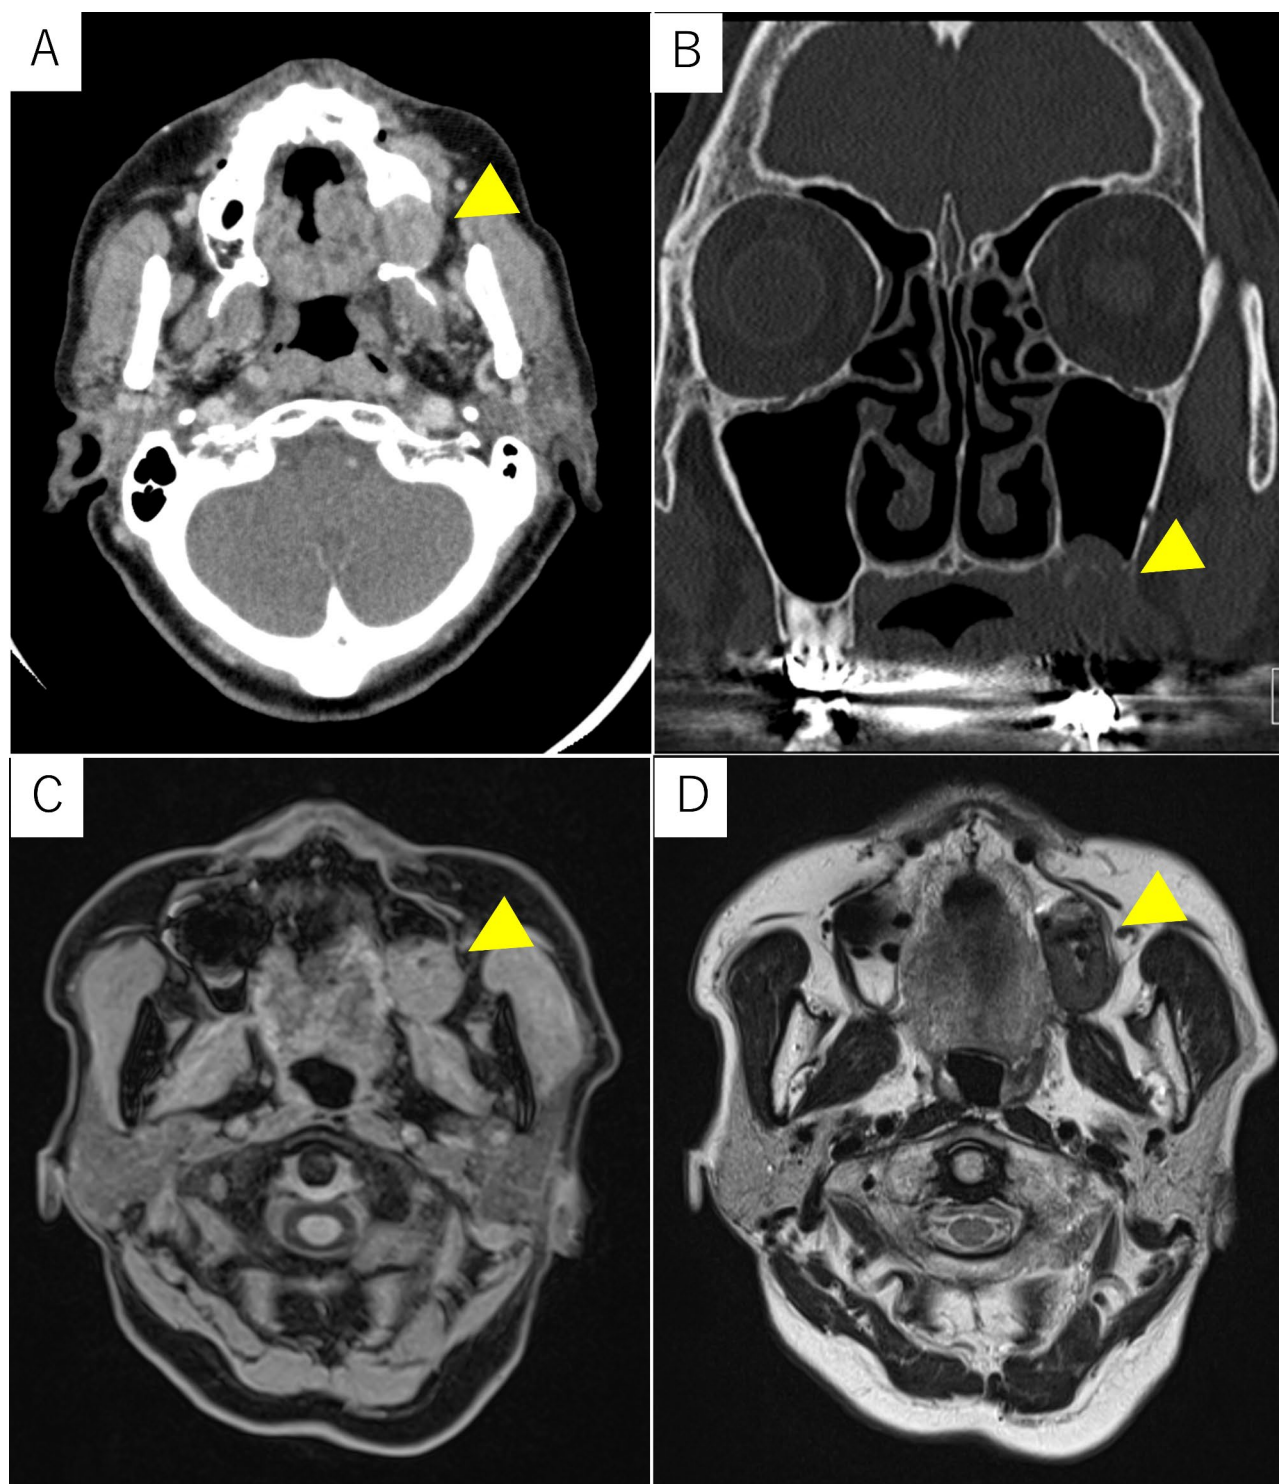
(A, B) Computed tomography of the presenting solid mass (arrow head) in the left maxillary bone. (A) Bone resorption caused by tumor compaction. (B) Compressive dome-shaped bulging and thinning of the inferior wall of the maxillary sinus, observed from the left maxillary alveolar area. (C, D) Magnetic resonance imaging. (C) T1-weighted image of an occupying lesion with well-defined borders and isointensity with muscle. (arrow head) (D) The lesion exhibited low signal in a T2-weighted image. (arrow head)
